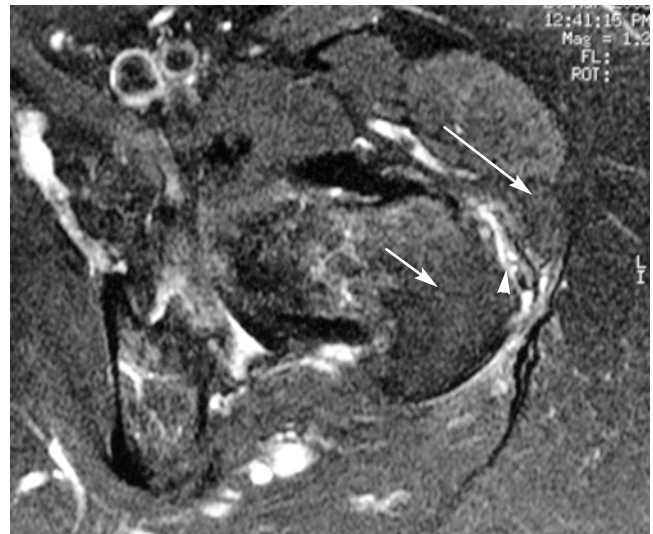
MRI transverse section of the greater trochanter (short arrow) showing the separation of the gluteus medius (long arrow). Synovial fluid was present between the detached tendon and trochanter (arrowhead).
